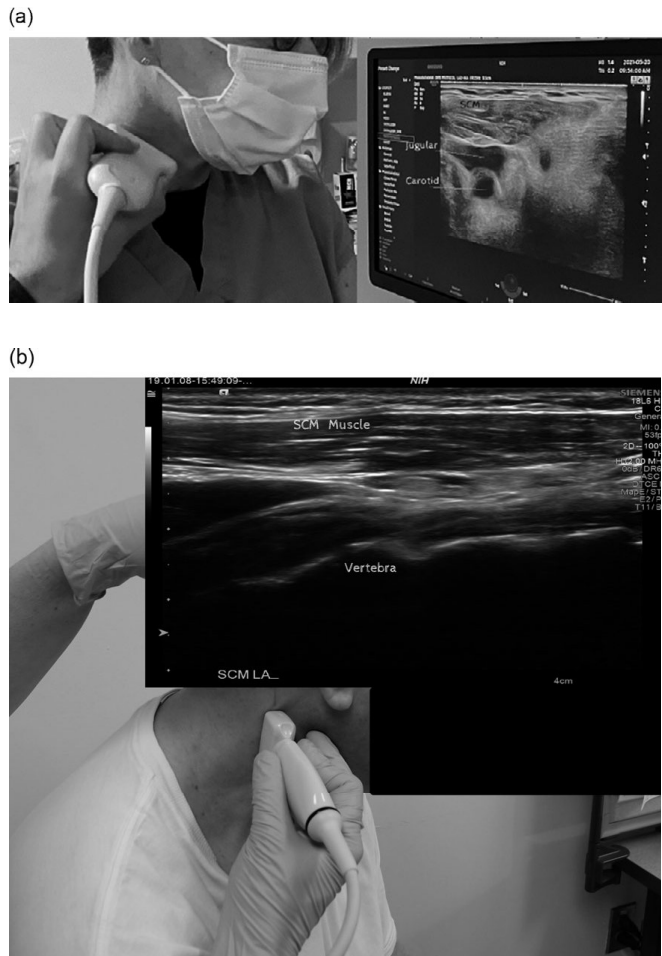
(a) Short-axis (cross-sectional) ultrasound scan, anterior cervical region. (b) Long-axis (longitudinal) B-mode ultrasound scan, sternocleidomastoid muscle, anterior cervical region.
